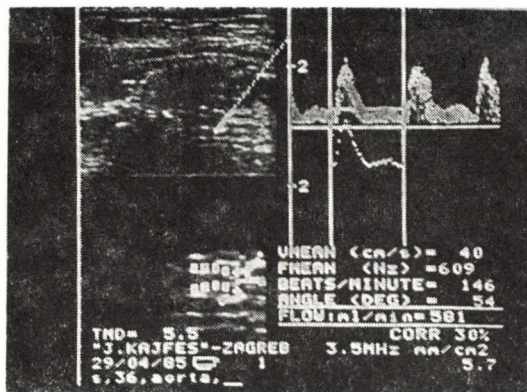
Blood flow in descending aorta of a 36 weeks old fetus. *Left side, above*, cross-section of fetus and aorta. The direction of the Doppler beam is indicated by the dotted line, and at its end the traced line shows the sample volume of Doppler ultrasound. The straight line enclosing an angle of 54° with it, with a cross at the end, reveals the angle between the ultrasound beam and the examined vessel. *Left side, down*: enlarged part of the aorta. The squares and cross show its diameter. Measurement was repeated five times, the average can be read directly off the figure (TMD = 5.5). *Right side, above* specific waveform of the aorta. *Right side, bottom* calculated data can be read off
